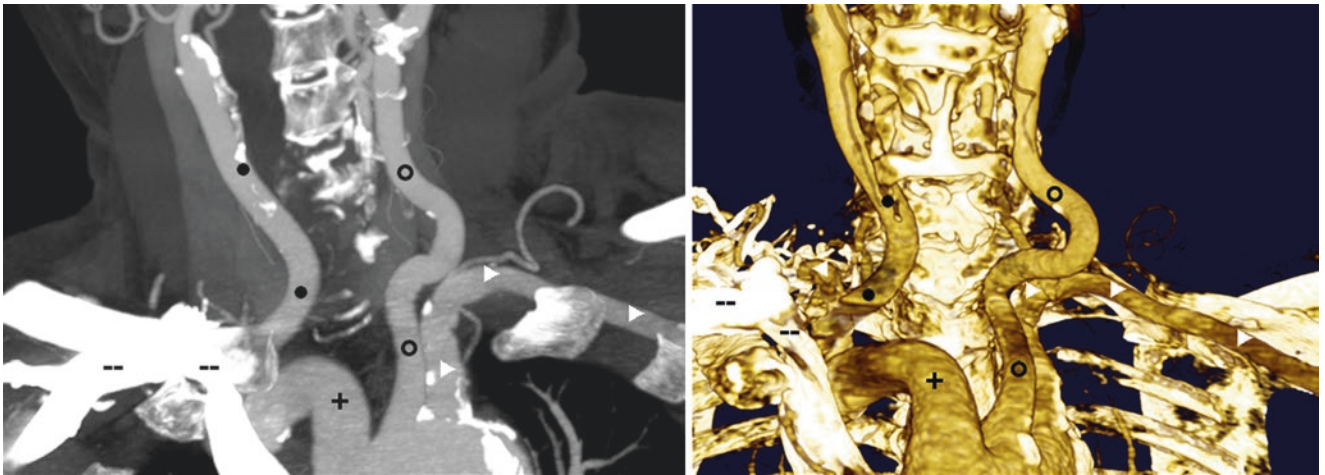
86-year-old with atherosclerotic calcifications of the great vessels' origins on CTA, with a tortuous IA (plus signs), as well as RCCA (black circles) and LCCA (open circles) origins, on a 34 mm-thick MPR coronal-LAO view (left), and on a 3D VR AP view (right).
